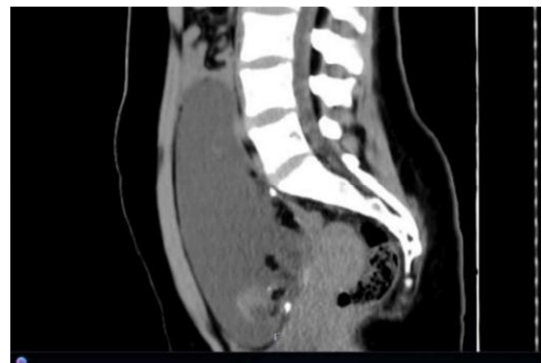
Pelvic CT sagittal images.
